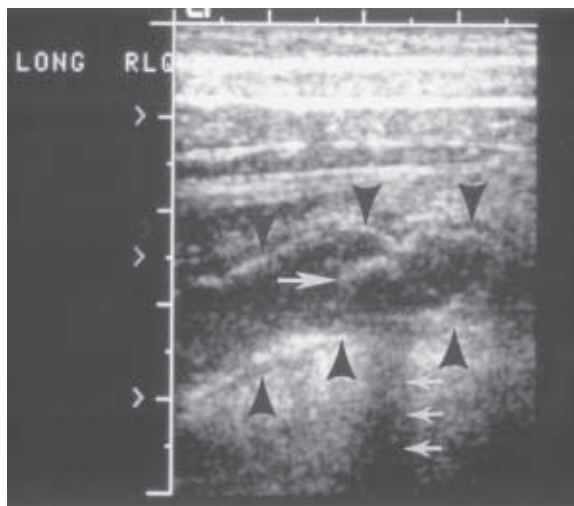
Appendicitis without perforation. On sonography, the appendix (arrowheads) is seen as a blind-ending tubular structure, approximately 1 cm in diameter. Note appendicolith (large arrow) with posterior acoustic shadowing (small arrows).
